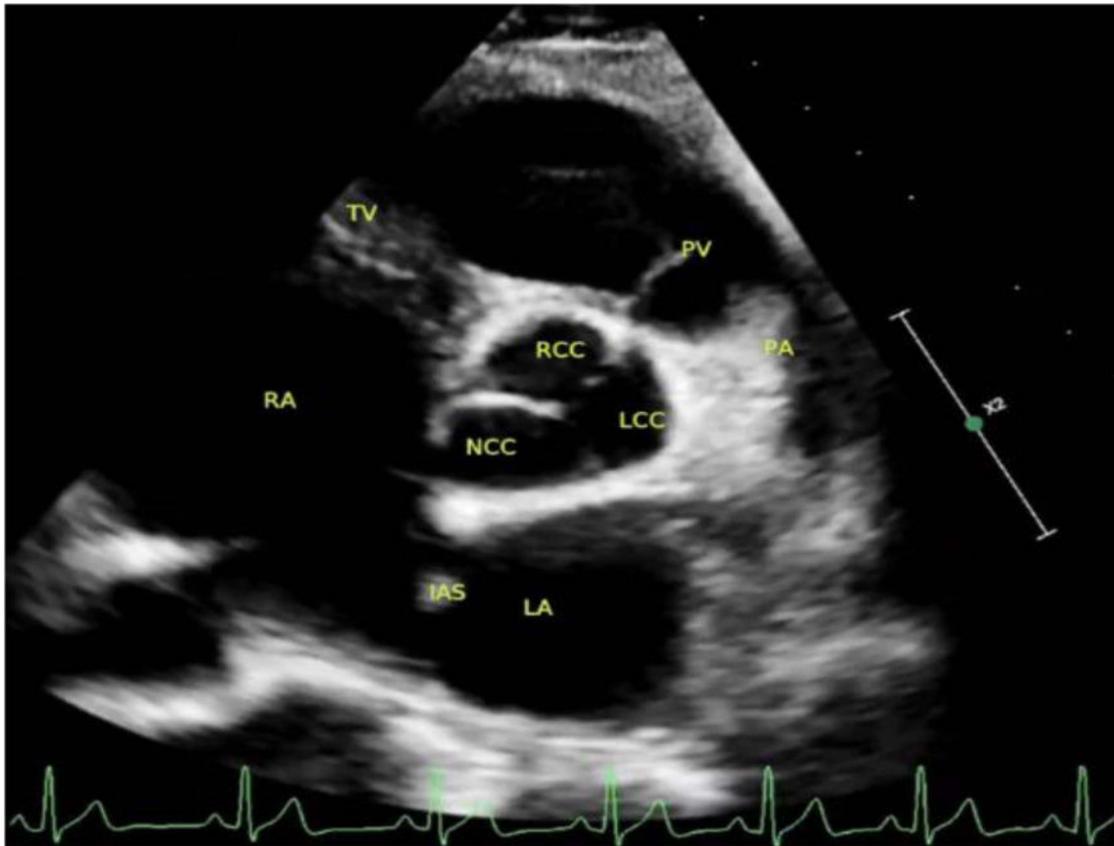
Parasternal short-axis (PSAX) at the aortic valve level.
